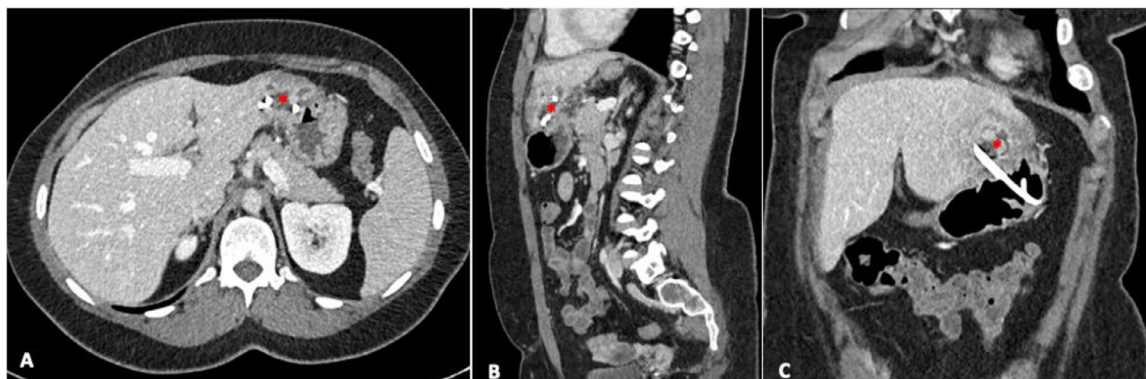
Axial (A), sagittal (B), and coronal (C) contrast-enhanced abdominal CT performed 3 days after endoscopic drainage, showing reduction of the abscess's size (red asterisks).
